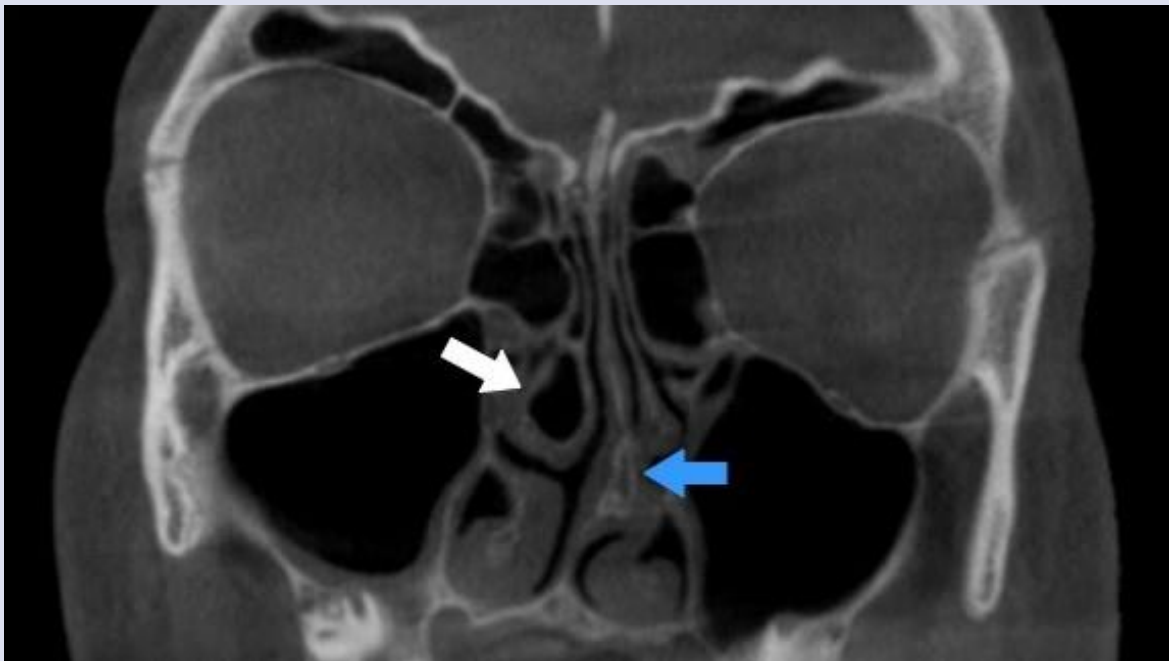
Coronal CBCT image; right concha bullosa (white arrow) and nasal septum deviation to the left (blue arrow).
